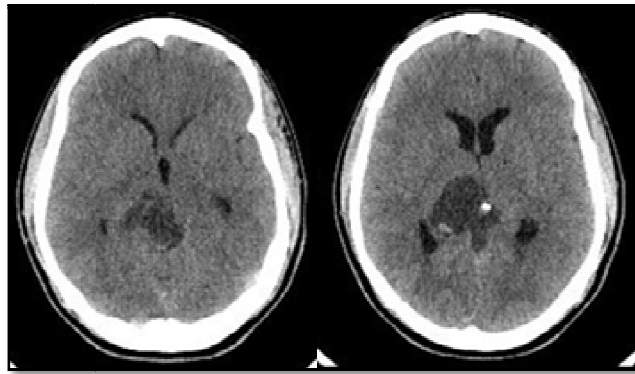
Non-contrast axial head CT showing a hypodense mass lesion in the right thalamus extending to the pineal region.
